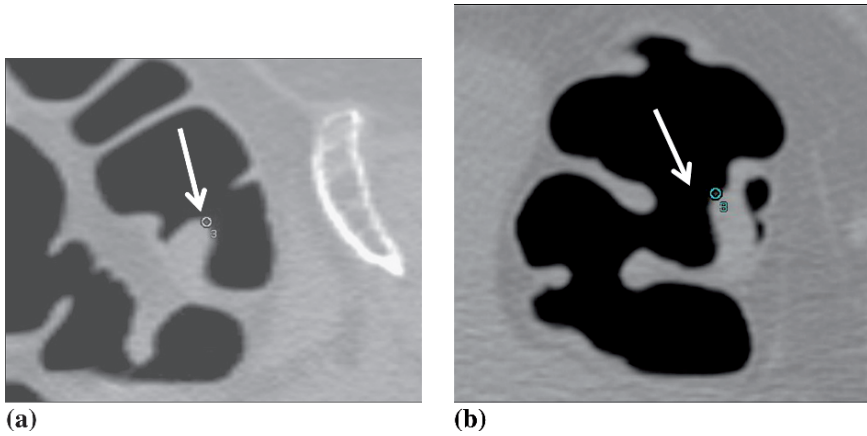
10mm pedunculated polyp seen on CT colonography. The polypoid lesion appears to slightly modify its location between the supine (a, arrow) and prone (b, arrow) positions. The short stalk is also seen on b (open arrow)
